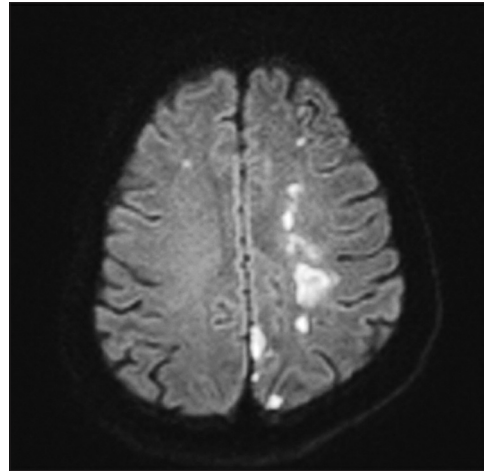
Diffusion-weighted magnetic resonance imaging image of coronal cut section of brain showing restriction in watershed zone of superficial and deep territories of left middle cerebral artery
